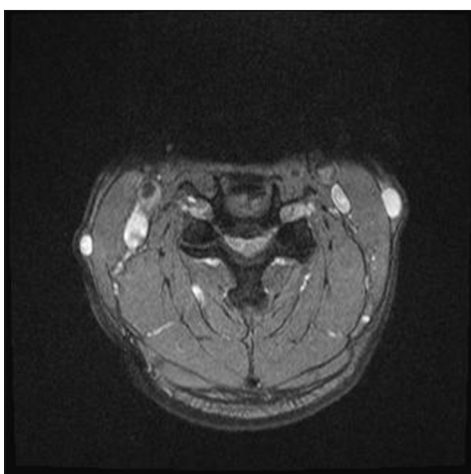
Axial T2-weighted STIR MR image at the C4-C5 disc space following the CSS. On the axial T2 weighted STIR MR image at the C4-C5 disc space level following the CSS one can see the marked reduction in the anterior-posterior diameter of the spinal canal to 5–6 mm secondary to ventral osteophyte formation vs. disc, and dorsal laminar shingling. On this STIR study, there also appears to be an increased signal in the cord at this level
